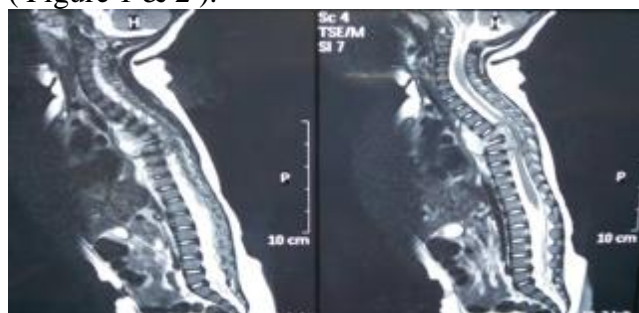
Sagittal view of MRI Spine T₂ weighted.
